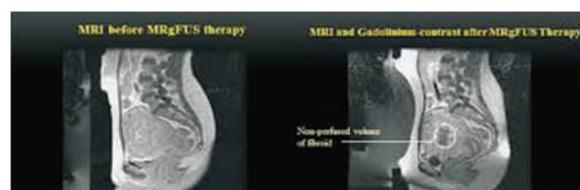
MRI image of MRgFUS therapy
